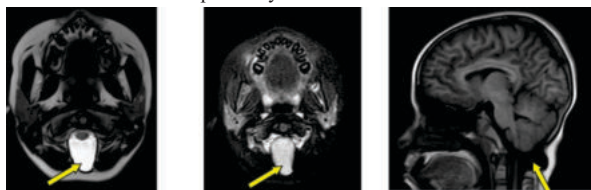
10 year old patient with h/o seizure 5 days back. T1, T2, FLAIR shows protrusion of occipital meninges at the level of foramen magnum - Occipital meningocele
